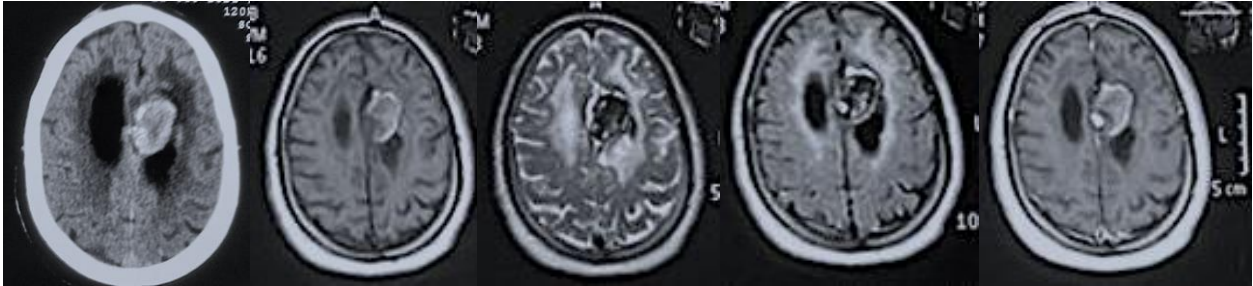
Pre-operative imaging. Axial sections of non-contrast head CT scan (A) as well as T1 (B), T2 (C), FLAIR (D), and gadolinium-enhanced T1 (E) MRI show a left frontal parasagittal (supracallosal) mass that appears hyperdense on CT and heterogenous on MRI, with contrast enhancement of the posteromedial part of the lesion.
